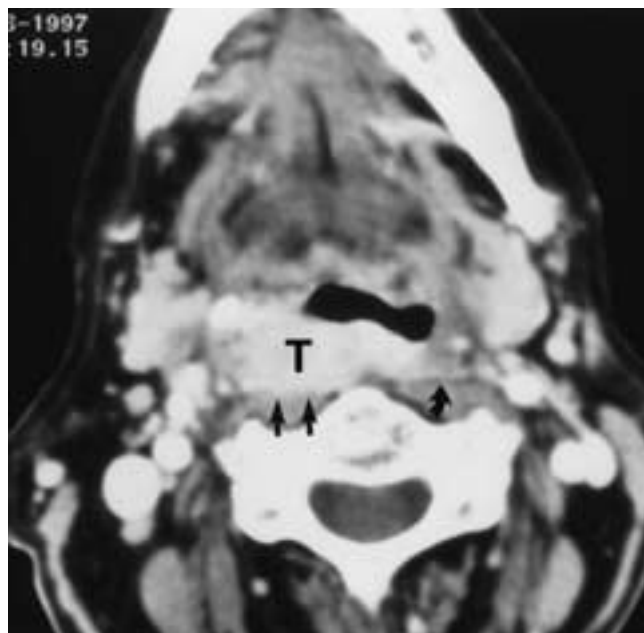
Axial contrast-enhanced CT scan demonstrates a posterior pharyngeal wall carcinoma situated at the level of the oropharynx (T). Note the obliteration of the fat plane between the tumor and the underlying right longus colli muscle (straight arrows). Compare this to the normal appearance on the left side (curved arrow).
